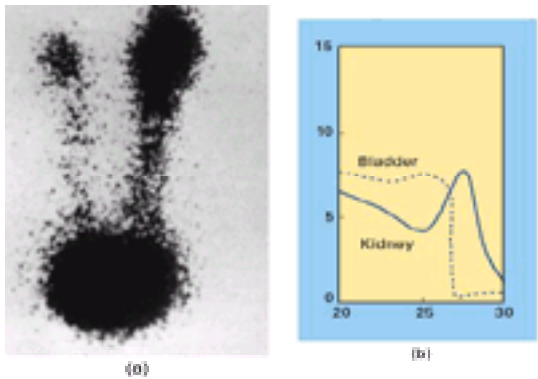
(a) A direct voiding cystoureterogram using technetium-99m as pertechnetate in saline instilled into the bladder via a catheter while the patient voids; there is gross reflux up both ureters. (b) Indirect voiding cystoscintigraphy. Towards the end of the descending phase of a renogram done with technetium-99m DTPA, this child was asked to void. The activity curve over the bladder drops precipitously, but at the same time the renogram rises to reflect increased activity over the kidney due to reflux.
